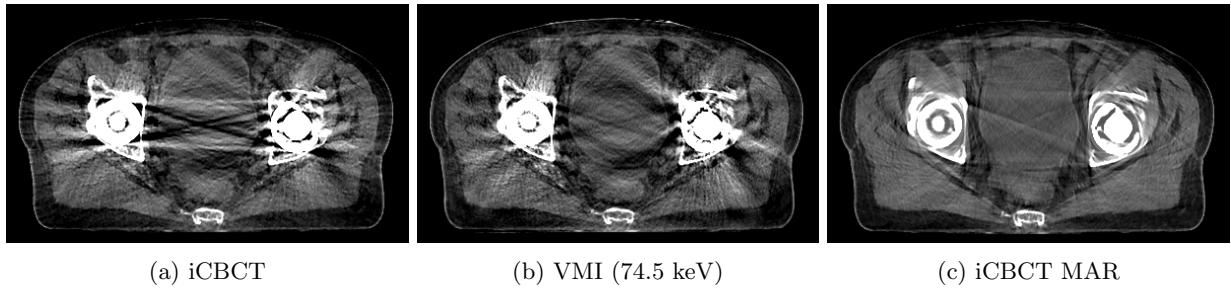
Metal artifact within bladder region is reduced in the VMI from polychromatic reconstruction (middle) as compared to a standard iCBCT reconstruction (left). As a reference, an iCBCT reconstruction with heuristic metal artifact reduction (MAR) is shown on the right. W/L = 500/75 HU. Patient data courtesy of Queen’s Hospital in Romford
